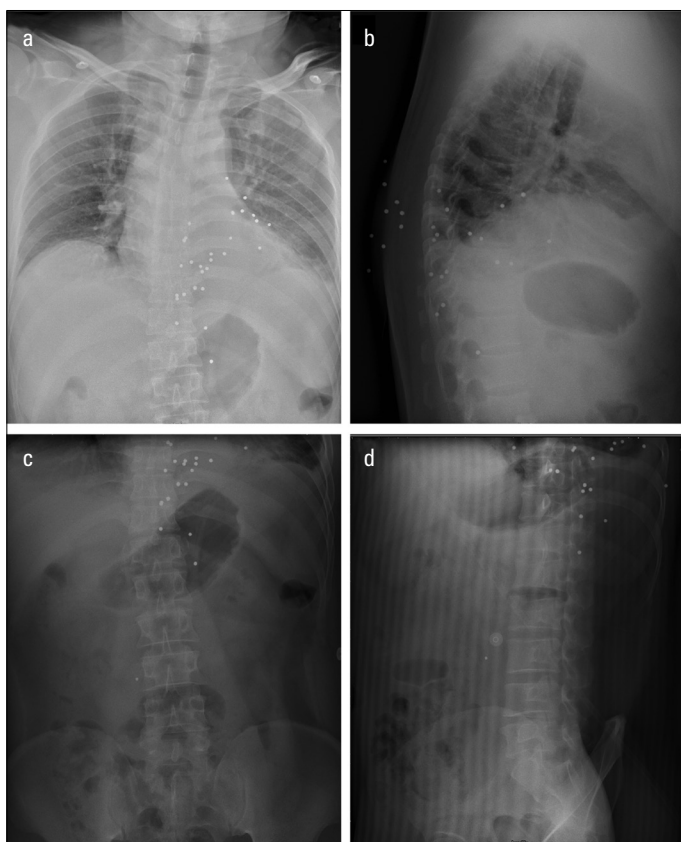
X-ray image showing grainy high-density shadows in the chest and abdomen
